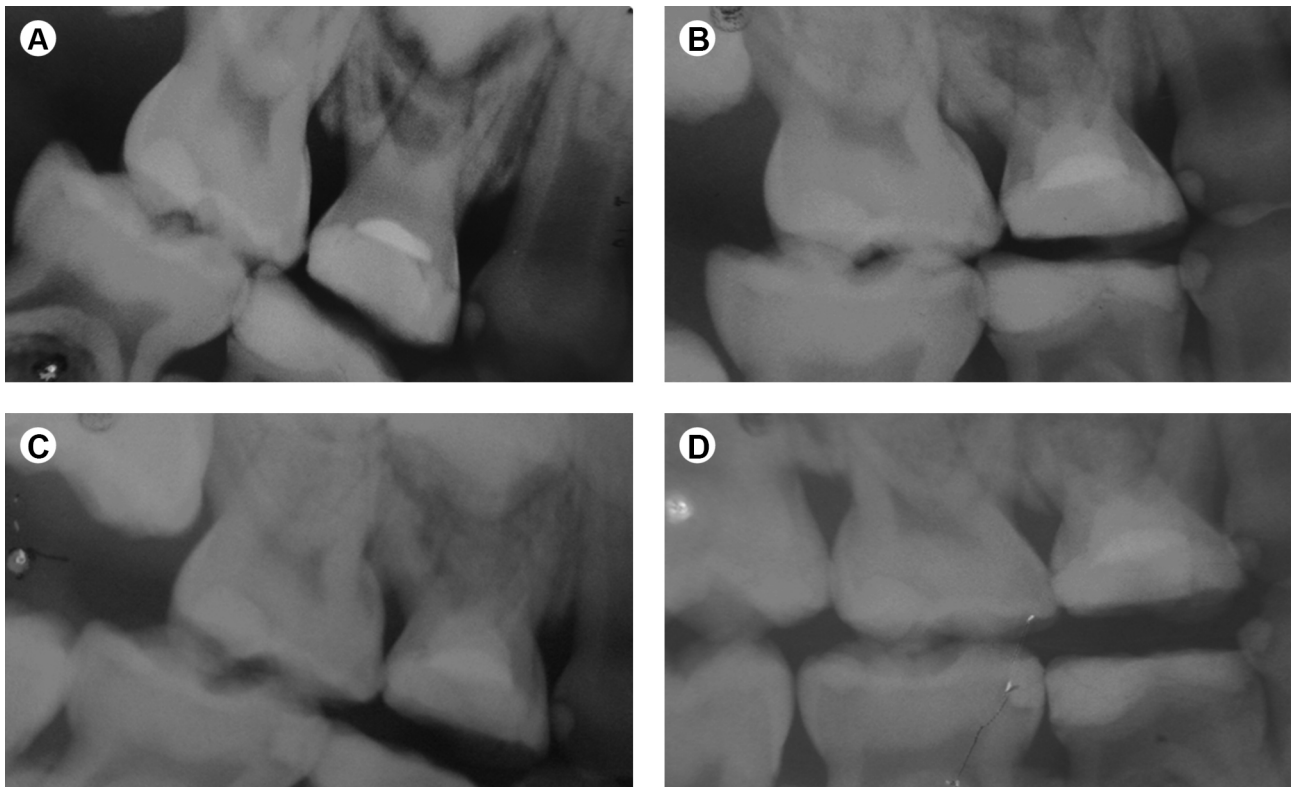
Radiographs of a maxillary first primary molar (54) considered as treatment success at 12-month follow-up. (A) Pre-operative radiograph showing slight thickening of the periodontal ligament and furcation radiolucency. (B) Post-operative radiograph after endodontic treatment using calcium hydroxide paste with zinc oxide (3:1 weight proportion). (C) Radiograph taken 6 months postoperatively showing improvement of furcation radiolucency. (D) The tooth was judged success at 12 months, showing absence of inter-radicular radiolucency and periodontal ligament integrity.
